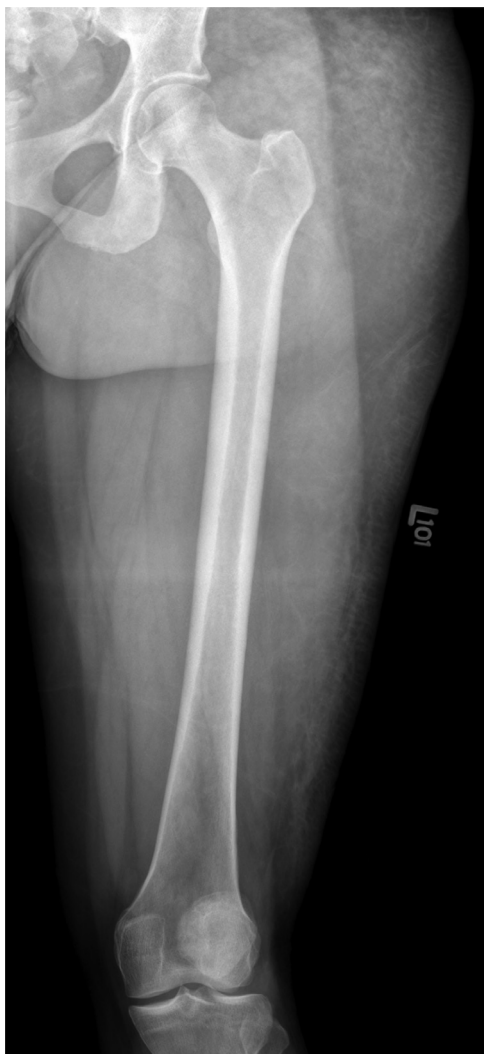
Anteroposterior radiograph of the left thigh demonstrated mild distal lateral thigh soft tissue prominence without a soft tissue calcification or ossification. Note the foci of increased soft tissue densities in the left gluteal region.
